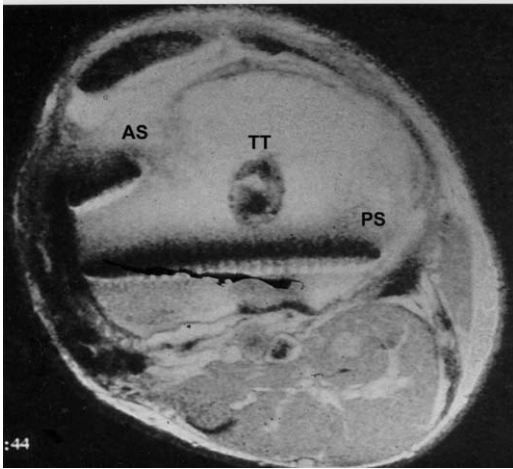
Axial MR image of the proximal tibia from a patient who underwent combined HTO and ACL reconstruction. The screws are placed in a divergent fashion and the anterior screws are short to allow proper placement of the tibial tunnel for the ACL reconstruction. (From Williams RJ, Wickiewicz TL, Warren RF. Management of unicompartmental arthritis in the anterior cruciate ligament-deficient knee. *AJSM* 2000;28:5; with permission.)
